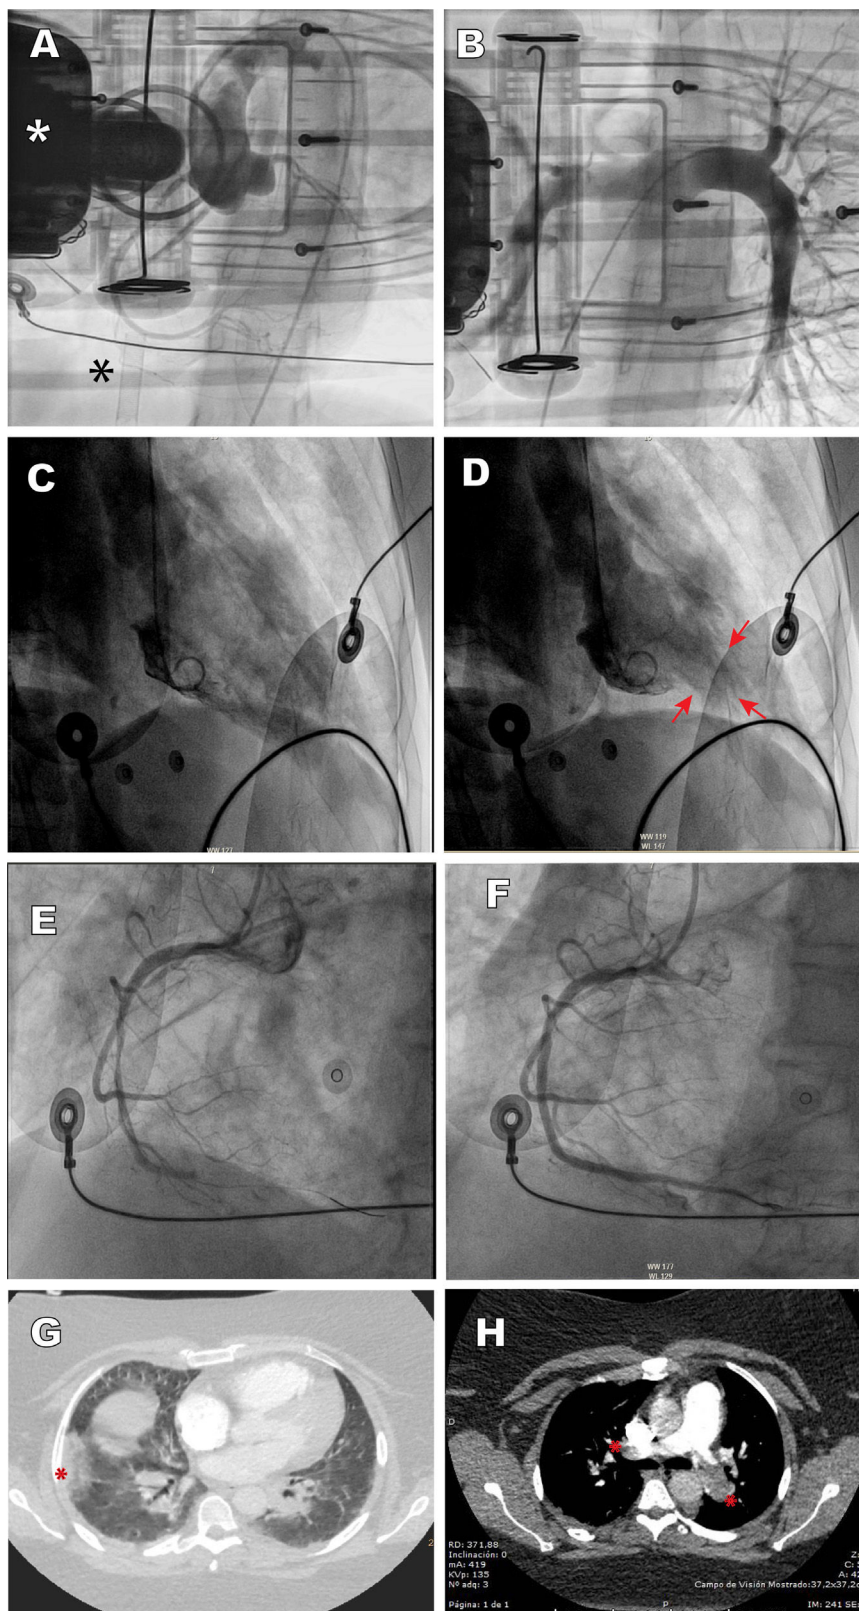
A: case 1, aortography depicts a normal aorta and coronary arteries; the white asterisk indicates the chest compression device, and the black asterisk the venous cannula of the extracorporeal membrane oxygenator. B: case 1, pulmonary angiography shows normal findings. C and D: case 2, ventriculography depicts a pattern consistent with inverted tako-tsubo, diastole and systole; the arrows indicate apical hypercontractility. E and F: case 3, thrombotic occlusion of the mid segment of the right coronary artery and revascularization with stent implantation. G: case 4, CT angiography depicts pulmonary infarction (asterisk) and patchy peripheral opacities consistent with SARS-CoV-2 pneumonia. H: case 4, CT angiography shows thrombotic occlusion of both pulmonary arteries (asterisks). This figure is shown in full color only in the electronic version of the article.
